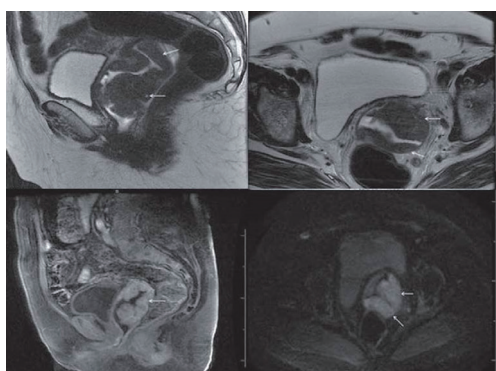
Magnetic resonance imaging of vaginal melanoma (26).
